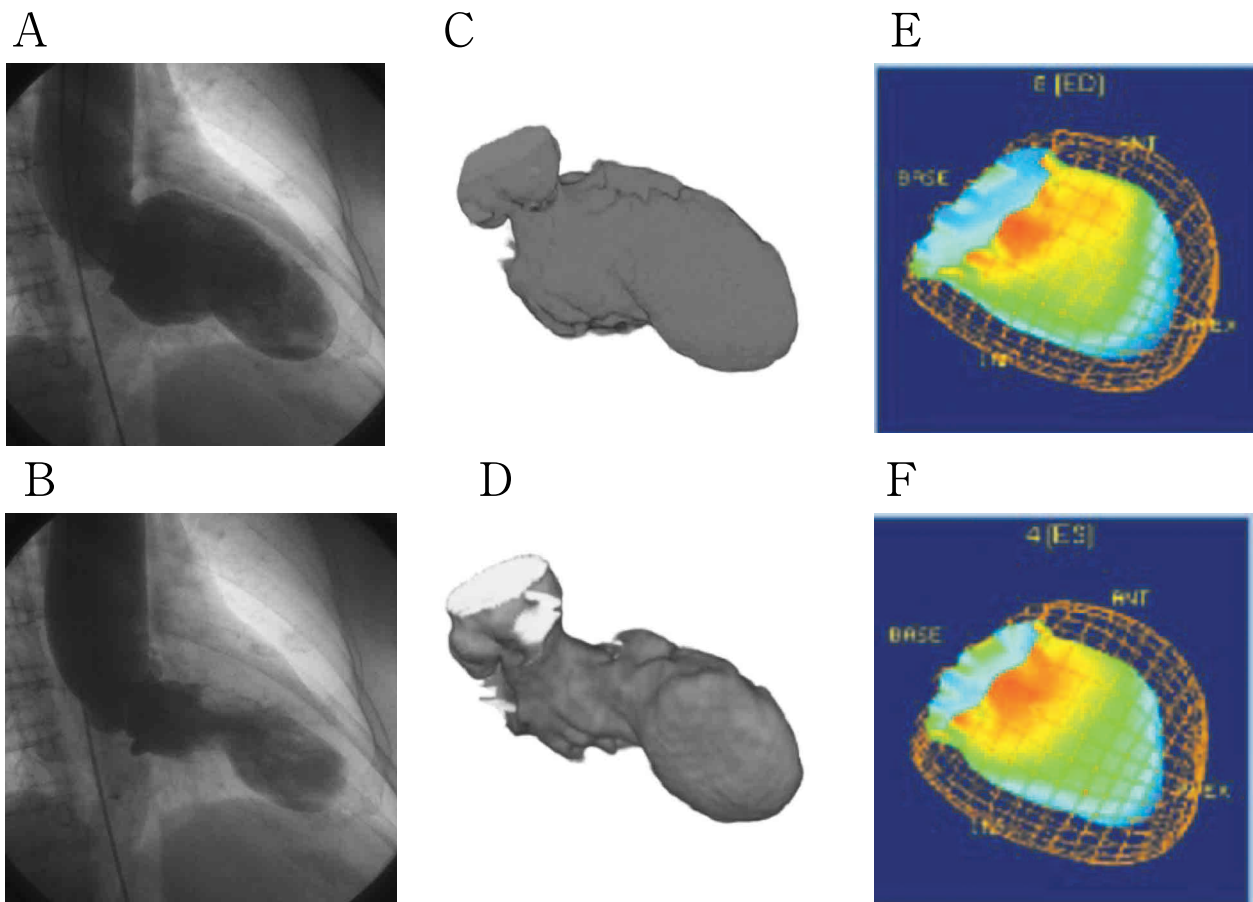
Left ventricular images in the RAO view, of a 65-year-old patient with a history of anterior myocardial infarction based on LVG (A : end-diastolic, B : end-systolic), MDCT (C : end-diastolic, D : end-systolic) and QGS (E : end-diastolic, F : end-systolic). RAO, 30-degree right anterior oblique ; LVG, left ventriculography ; MDCT, multidetector-row computed tomography ; QGS, quantitative gated SPECT.
